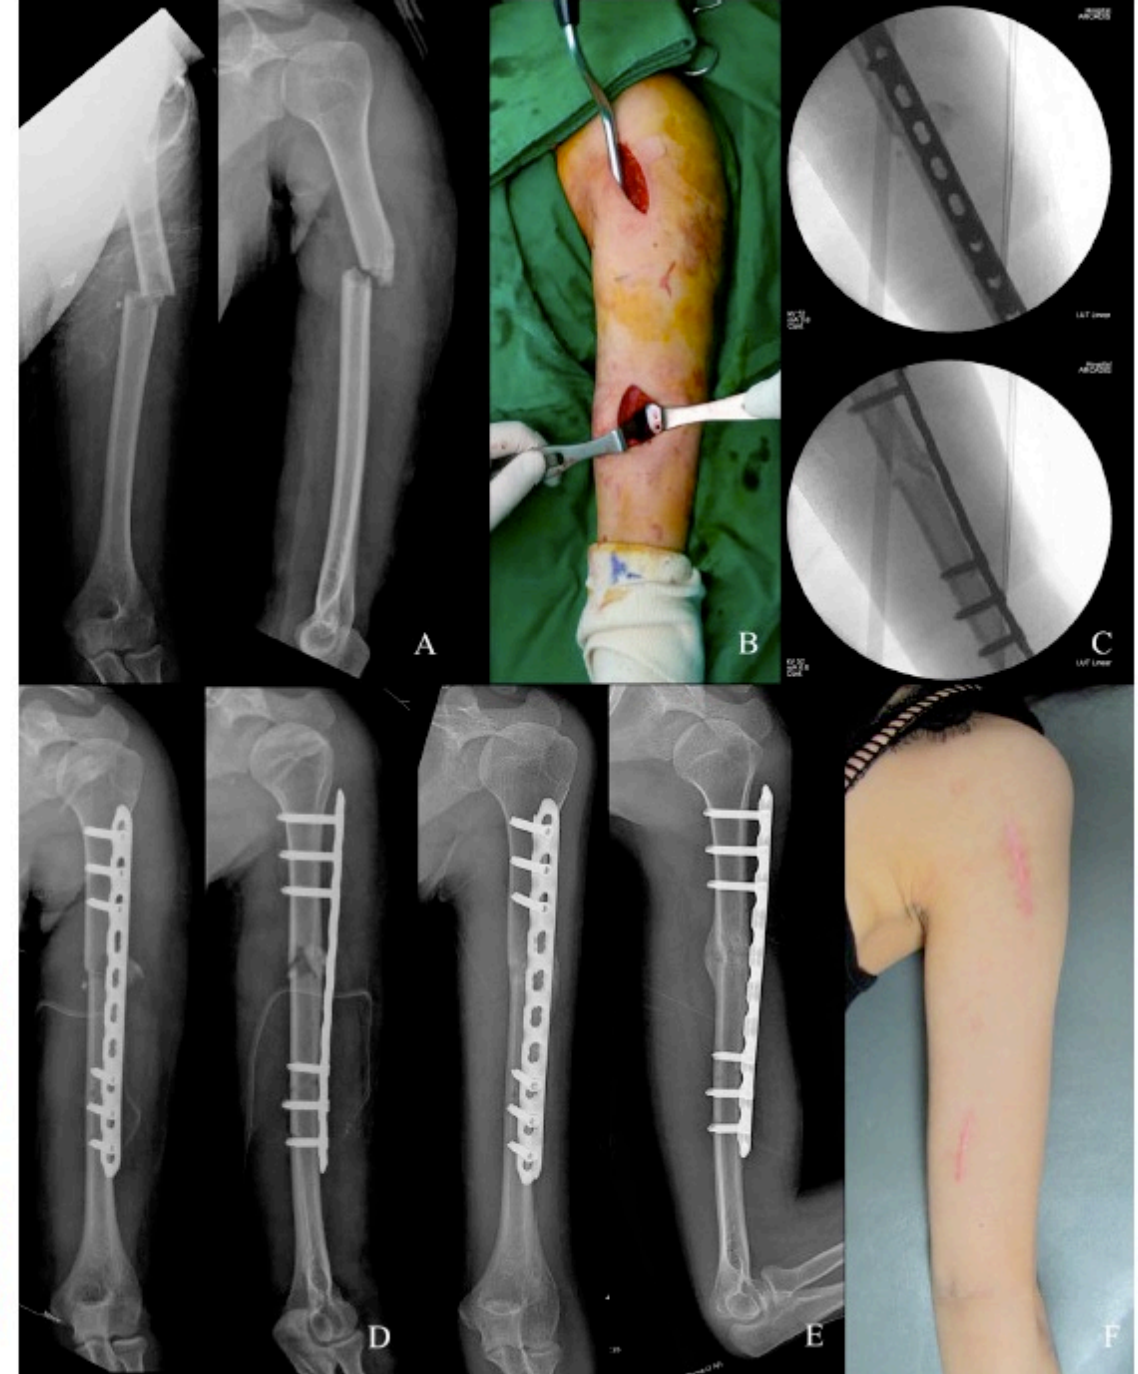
A, A 21-year-old woman sustained a fracture of the left humeral shaft (AO/OTA 12-A3) after a fall. B, The fracture was treated by MIPO. C, Under the image intensifier, the reduction state was verified. D, Post-operative radiographs show an acceptable alignment. E, The fracture was healed with callus formation 4 months after surgery, with a small incision scar and satisfactory function (F). Editor's note: A color image accompanies the online version of this article.
